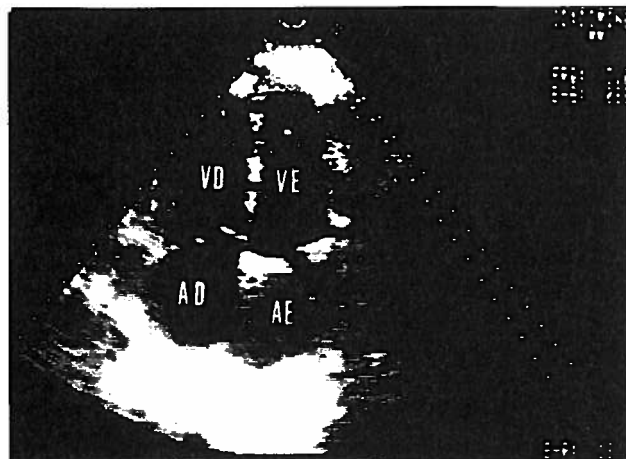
B-mode echocardiogram (4 chamber view): disappearance of the right atrial mass and dilatation of right cardiac chambers (see legend in fig 1).
